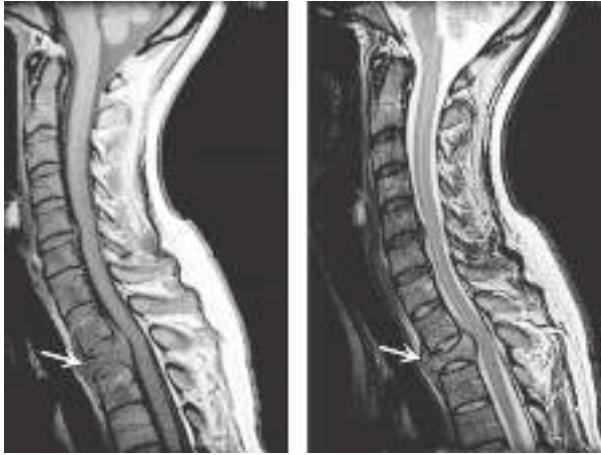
Epidural spinal cord compression due to breast carcinoma. Sagittal T1-weighted (*A*) and T2-weighted (*B*) magnetic resonance imaging scans through the cervicothoracic junction reveal an infiltrated and collapsed second thoracic vertebral body with posterior displacement and compression of the upper thoracic spinal cord. The low-intensity bone marrow signal in *A* signifies replacement by tumor.
